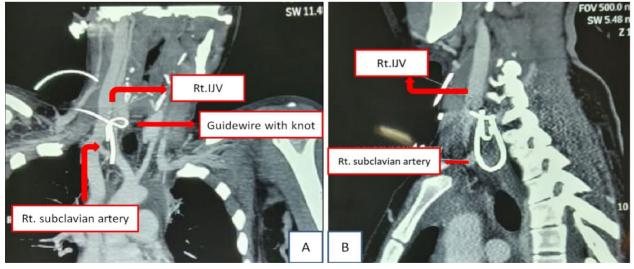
Computed Tomography showing the Right internal jugular vein (IJV), right subclavian artery and the guidewire knot.
